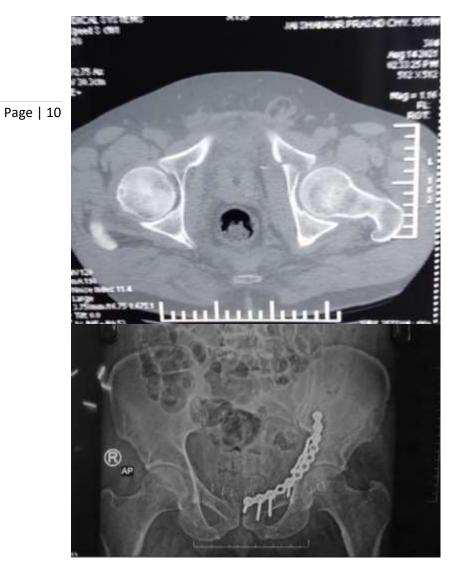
shows the CT Imaging of Case 2
